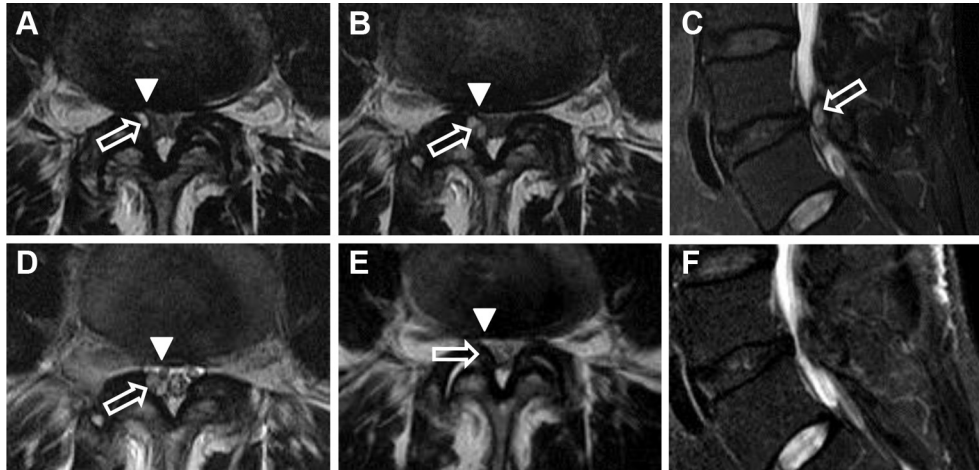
Serial magnetic resonance imaging (MRI) of spinal cyst (T₂ weighted). (A) Initial MRI scan. The cyst (open arrow) appears as a well-defined high signal intensity fluid collection arising from the right L4–L5 facet joint and protruding into the spinal canal, resulting in root (arrowhead) compression. (B,C) Six months after conservative treatment, the cyst was enlarged [(A) 0.3 × 0.5 cm; (B) 0.4 × 0.7 cm]. (D) One day after ultrasound-guided facet joint injection, the lesion was the same size, but the symptom, radiating pain, was partially relieved. (E,F) Four months after facet joint injection, the cyst had disappeared and the symptoms were completely relieved. (A,B,D,E) Axial scans through the L4–5 level. (C,F) Sagittal scans through the right facet joint of L4–5.
